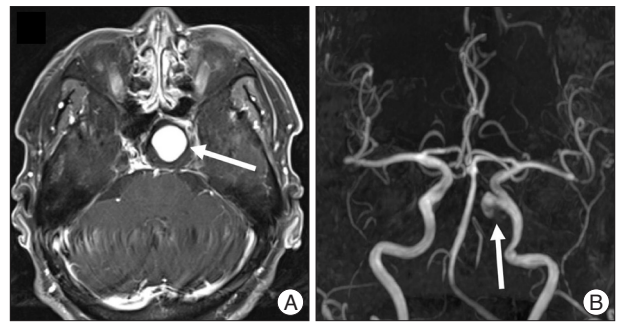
Pre-treatment magnetic resonance and angiographic images. T1-weighted post-gadolinium magnetic resonance image (A) and magnetic resonance angiography (B) showing a large aneurysm (arrows) arising from the left cavernous internal carotid artery and protruding into the sphenoid sinus.
